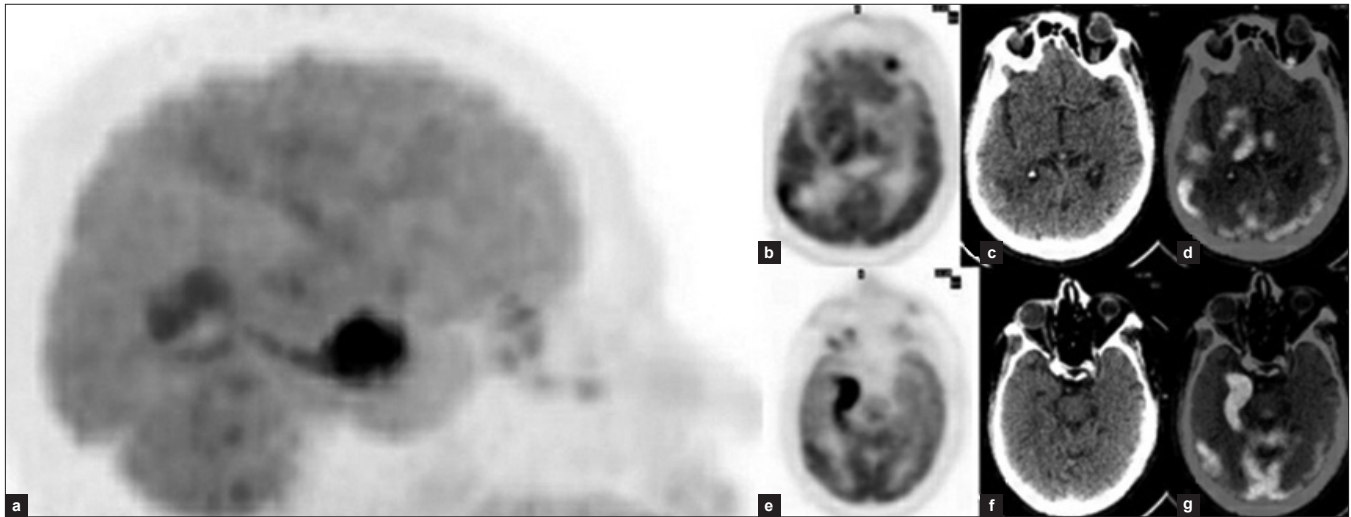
61-year male with Ca left lung post-chemo/RT with bone mets, sent for evaluation of response to therapy; (a) Lateral MIP of brain showing an intensely hyper-metabolic focus anteriorly and mild hyper-metabolism posterior to it; (b, c, d) Axial plain PET, LDCT and fused PET/CT images localize the posterior hyper-metabolic focus to the right temporo-parietal metastases corresponding to a hyper-dense lesion on NCCT; (e, f, g) Axial plain PET, LDCT and fused PET/CT localize the intensely hyper-metabolic focus to the right parahippocampal gyrus which appears normal on CT
